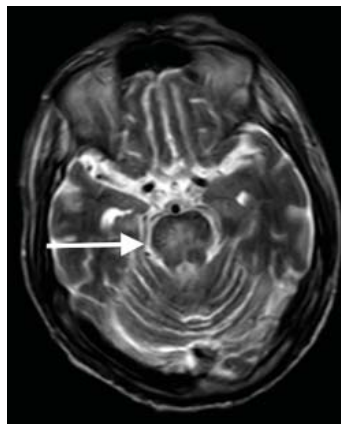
Axial T2-weighted magnetic resonance imaging on hospital day 5 showed a lesion with high signal intensity in the pons (arrow).
